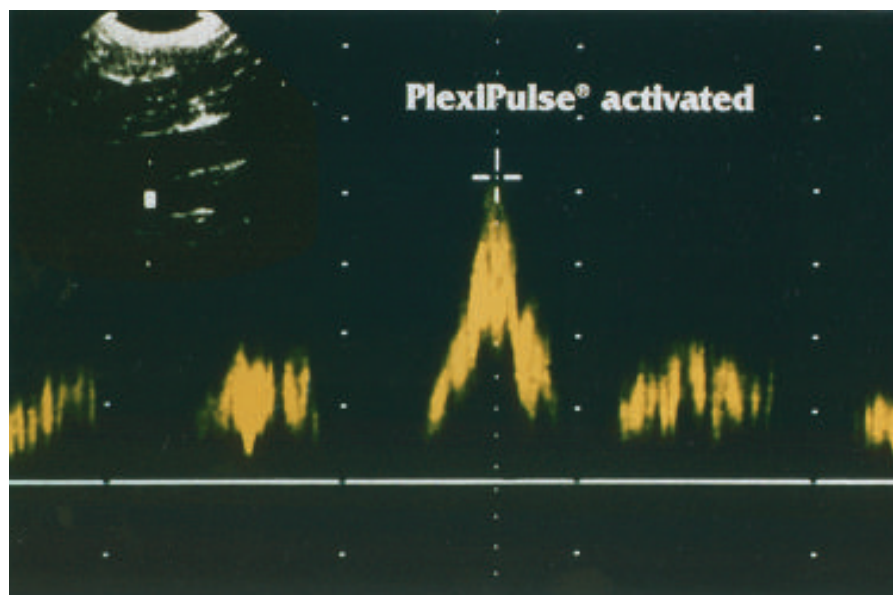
After activation of a Plexipulse™ pneumatic foot compression device, a venous Doppler examination at the popliteal vein demonstrates a significant increase in venous peak flow.
